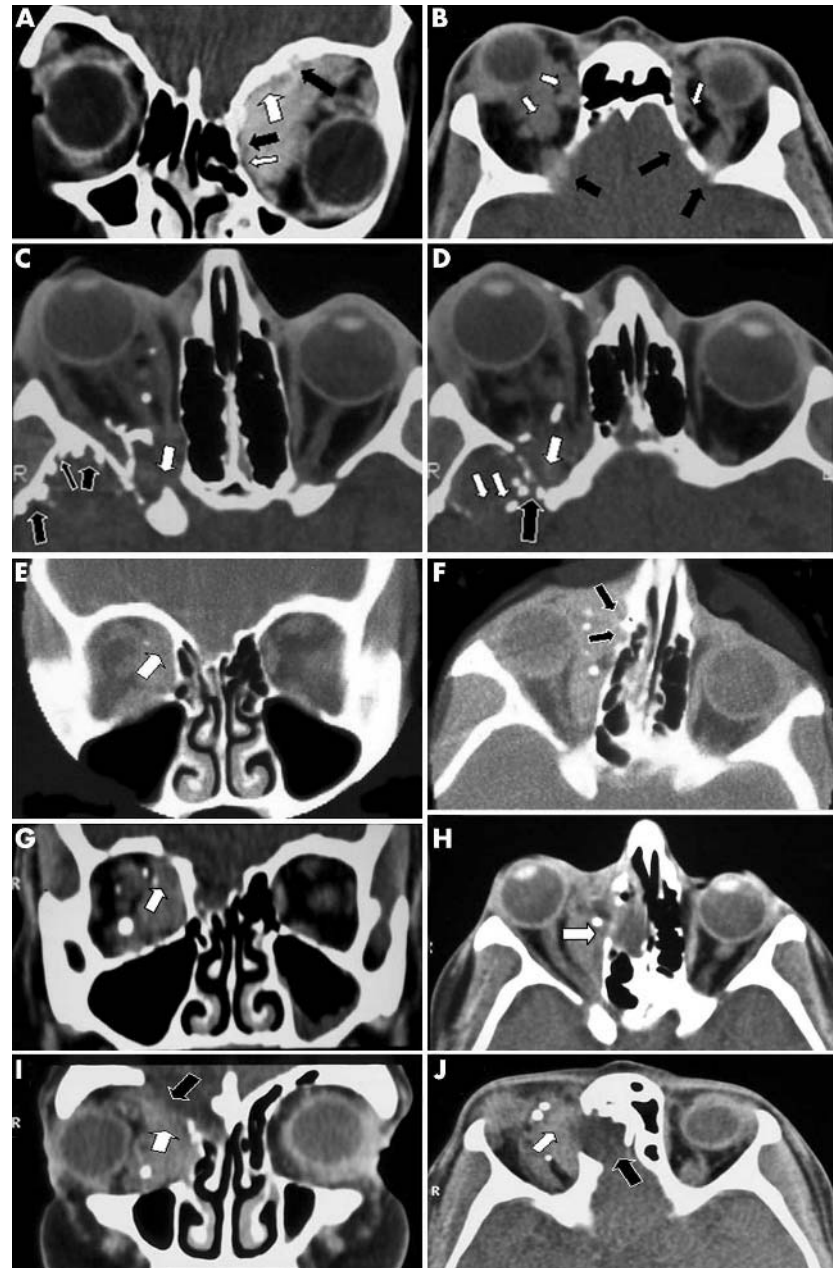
(A) (Patient 1) Extensive left orbital varices (white arrows) causing orbital expansion, globe displacement, and "pitting" of the orbital roof and lamina papyracea (black arrows). (B) (Patient 5) Bilateral orbital varices associated with multiple defects, rather than pitting, of the orbital walls. (C) (Patient 6) Right orbital varices, with phleboliths, extending through the orbital apex into the middle cranial fossa (white arrows) and (D) associated with intracranial bone "pitting" and "defects" (black arrows). (E) Coronal and (F) axial CT scans of patient 2 with superonasal varices (white arrows) of right orbit in 1981. (G-J) Repeat coronal and axial CT scans in 2001 show significant enlargement of the bone defect with complete loss of mineralisation, and expansion of the frontal lobe meninges into the orbital wall defect (black arrow).
